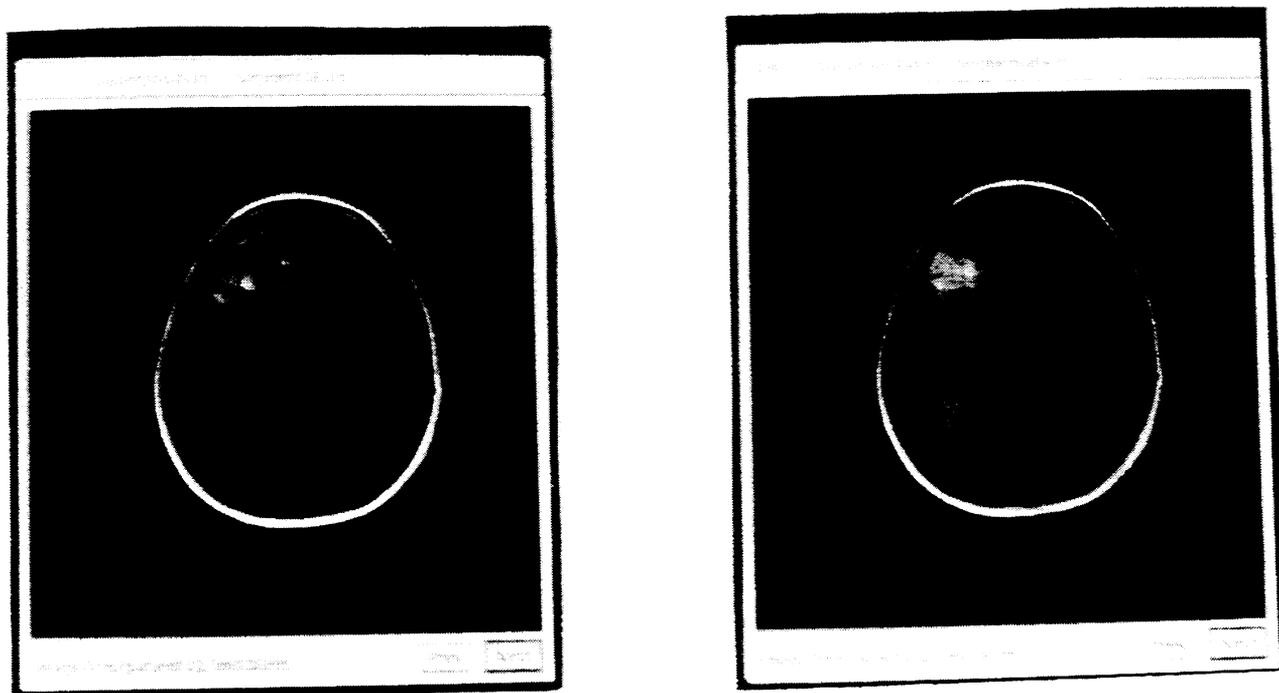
superimposition of MRI and resliced SPECT images after registration on the upper part of the patient's face, using an intermediate range imaging sensor linked to the SPECT device.
